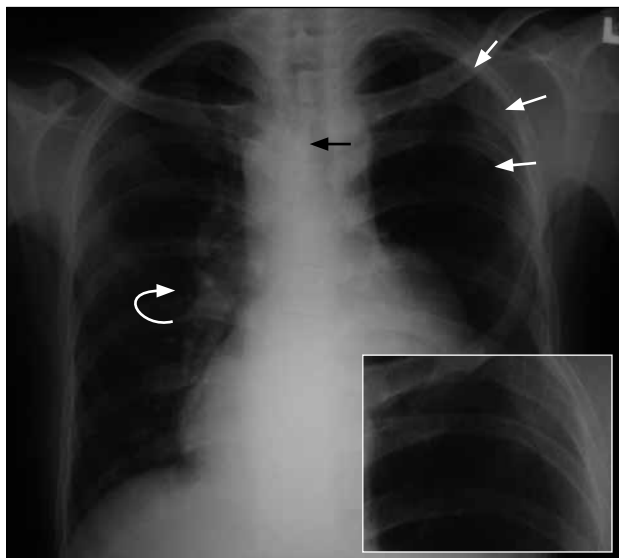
Plain chest radiograph of the second patient. There is cardiomegaly and a right-sided aortic arch (black arrow). The left lung is oligemic, and the left hilum is indistinct, while the right hilar vessels (curved white arrow) and pulmonary trunk are prominent. Rib notchings are present at the left 4th to 6th ribs (straight white arrows) [inset].
